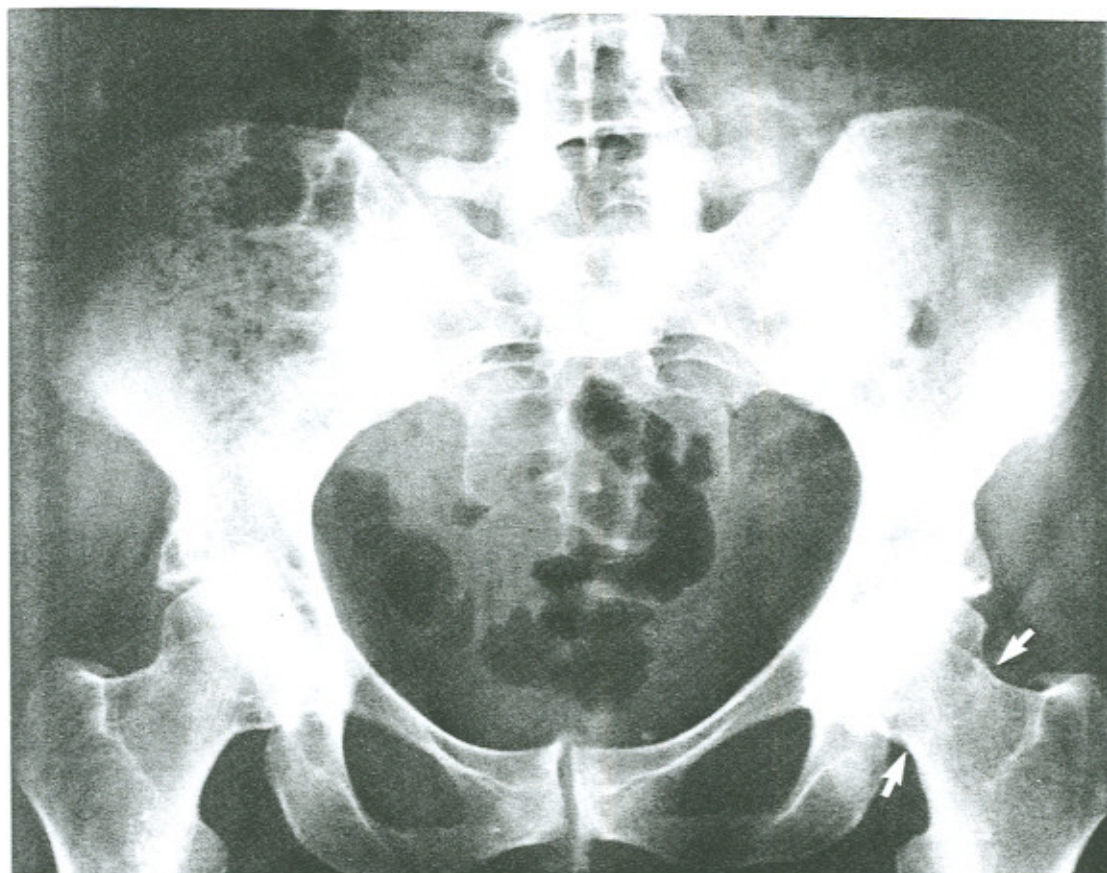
An AP pelvic radiograph reveals a linear, ill-defined sclerotic zone in the subcapital region of the left femur. (arrows)
